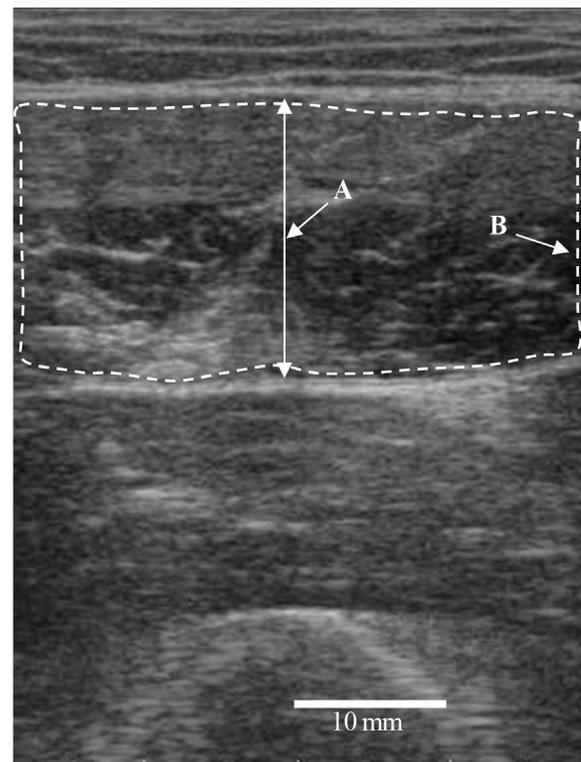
Ultrasound of the rectus femoris muscle.
